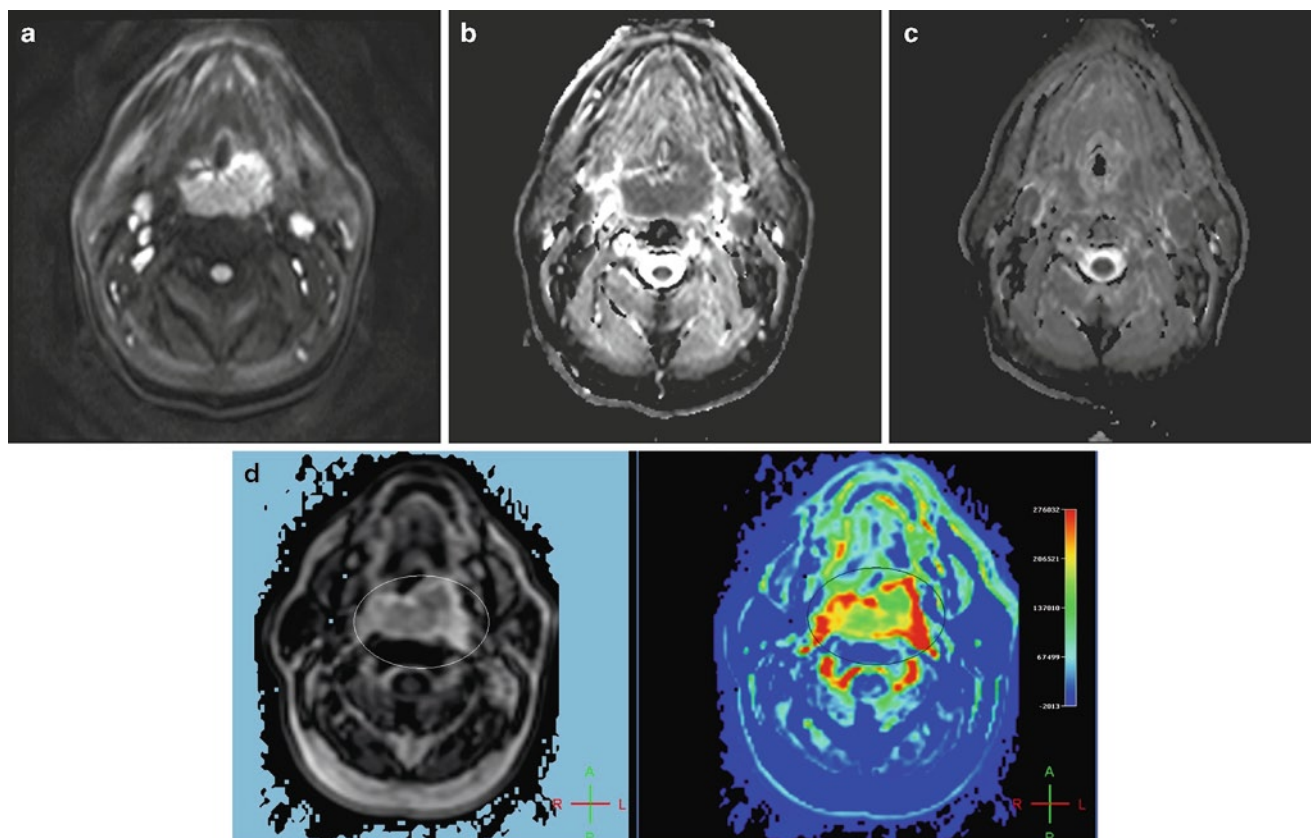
(a, b, c) Large posterior oropharyngeal wall squamous cell carcinoma demonstrates increased DWI (a) and decreased ADC (b) signal intensity at presentation. Posttherapy, the lesion has decreased greatly in size (c). (d) Blood volume map of the same
